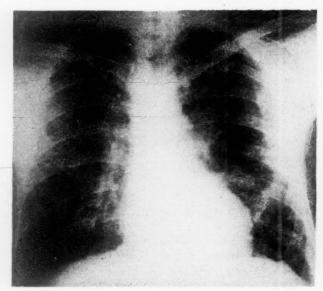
Case I. Roentgenogram of the chest taken on September 8, 1953, showing bilateral fan-shaped interstitial infiltration of the lungs.
